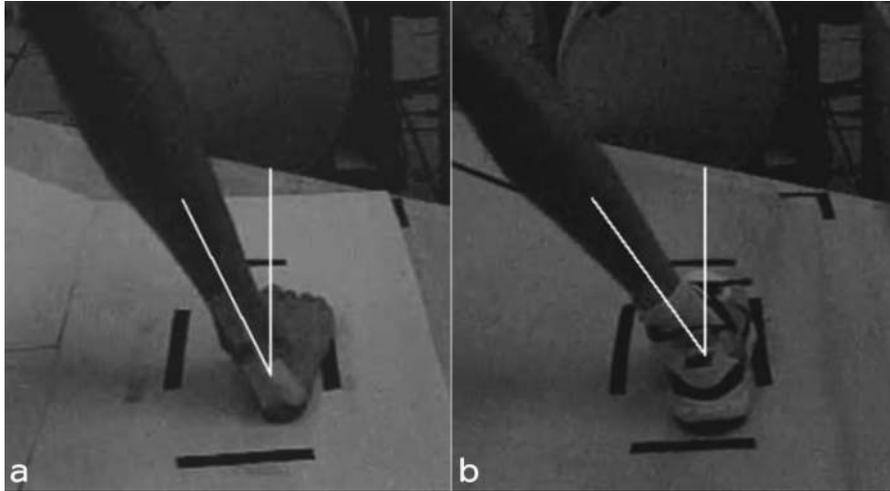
High-speed video stills during cutting in the x-ray field-of-view for one subject showing a representative difference in shank angle relative to the vertical plane when barefoot (a) versus shod (b).
